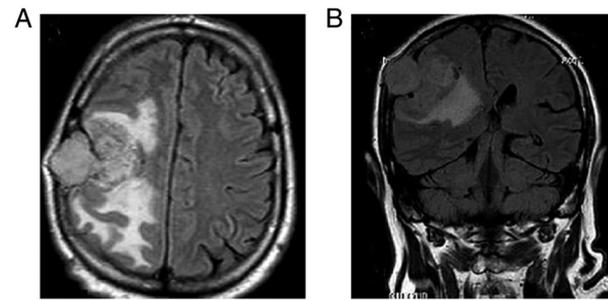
Case 1. (A) Axial and (B) coronal T2 FLAIR-weighted images of an extra-axial mass with mixed iso- and hyperintensity on the right cerebral convexity.
